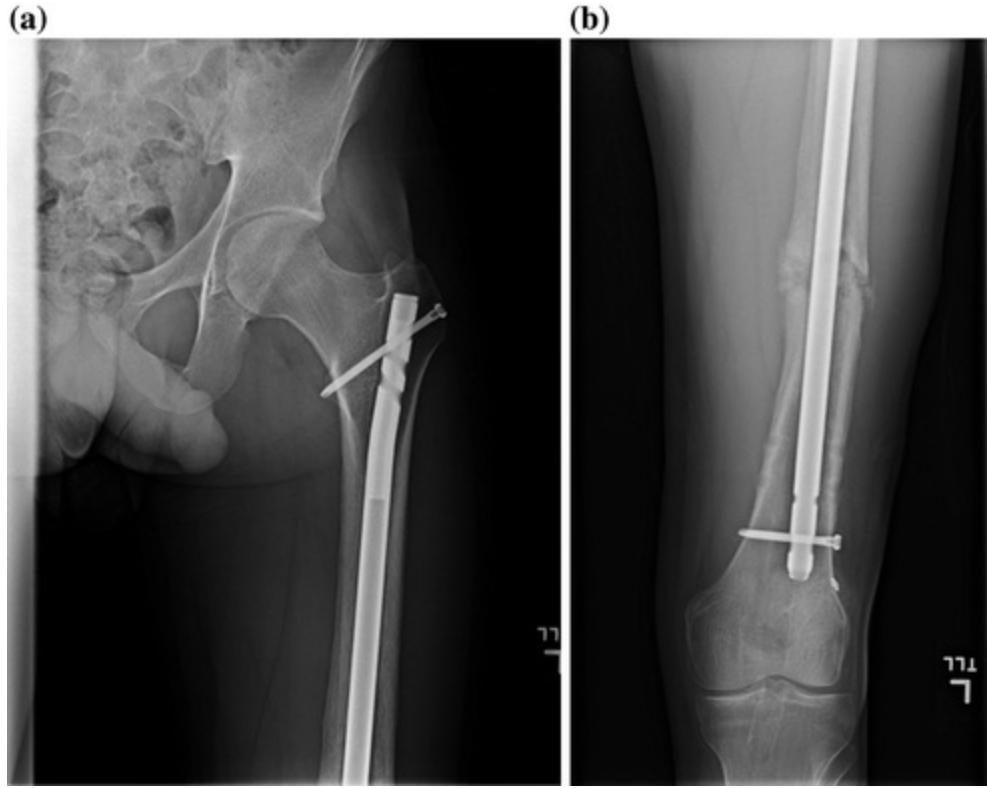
Femur X-rays after exchange nailing and bone grafting (a, b)
